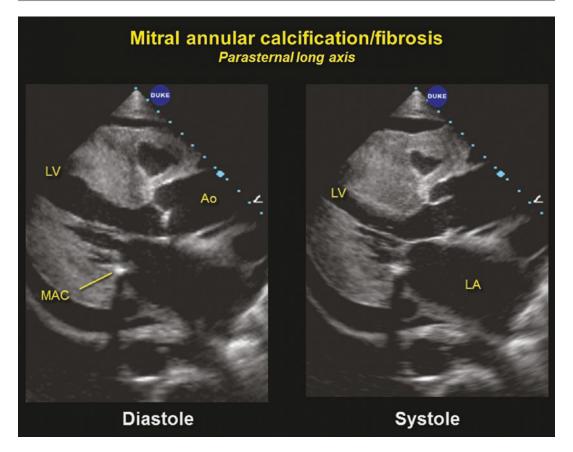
Parasternal long axis from a patient with renal failure and mitral annular calcification (arrow). Note the shadowing from the MAC. Echocardiography is not a
